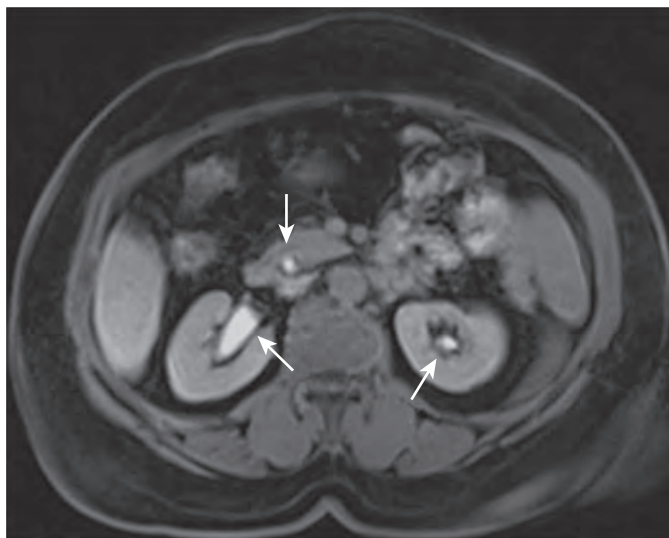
Gd-EOB-DTPA elimination: MR image. Gd-EOB-DTPA is eliminated through the biliary system (50%) and kidneys (50%).
